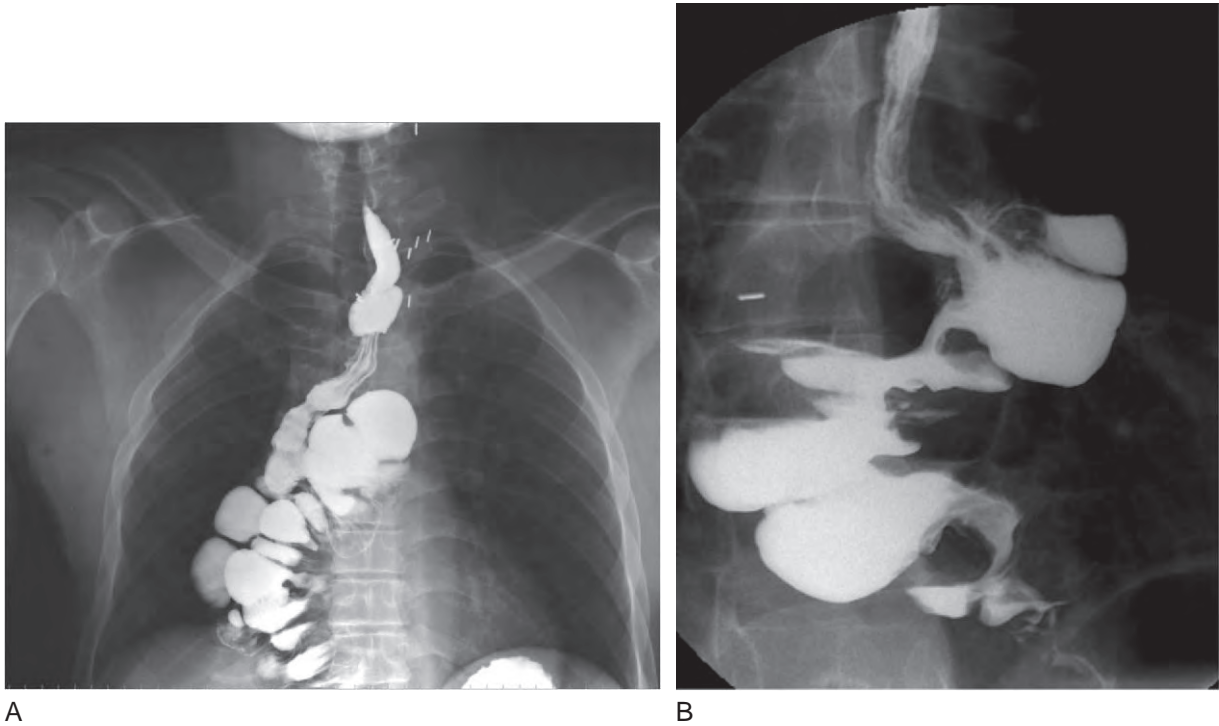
Substernal right colon interposition used to bypass a lye-induced esophageal stricture. A, Surgery was performed 22 years before this barium radiograph. B, Redundancy of the distal colon interposition developed over time.
